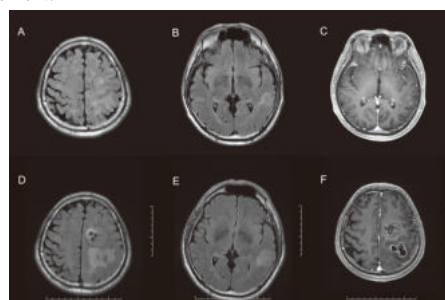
Cranial MRI images of the patient in case 2
